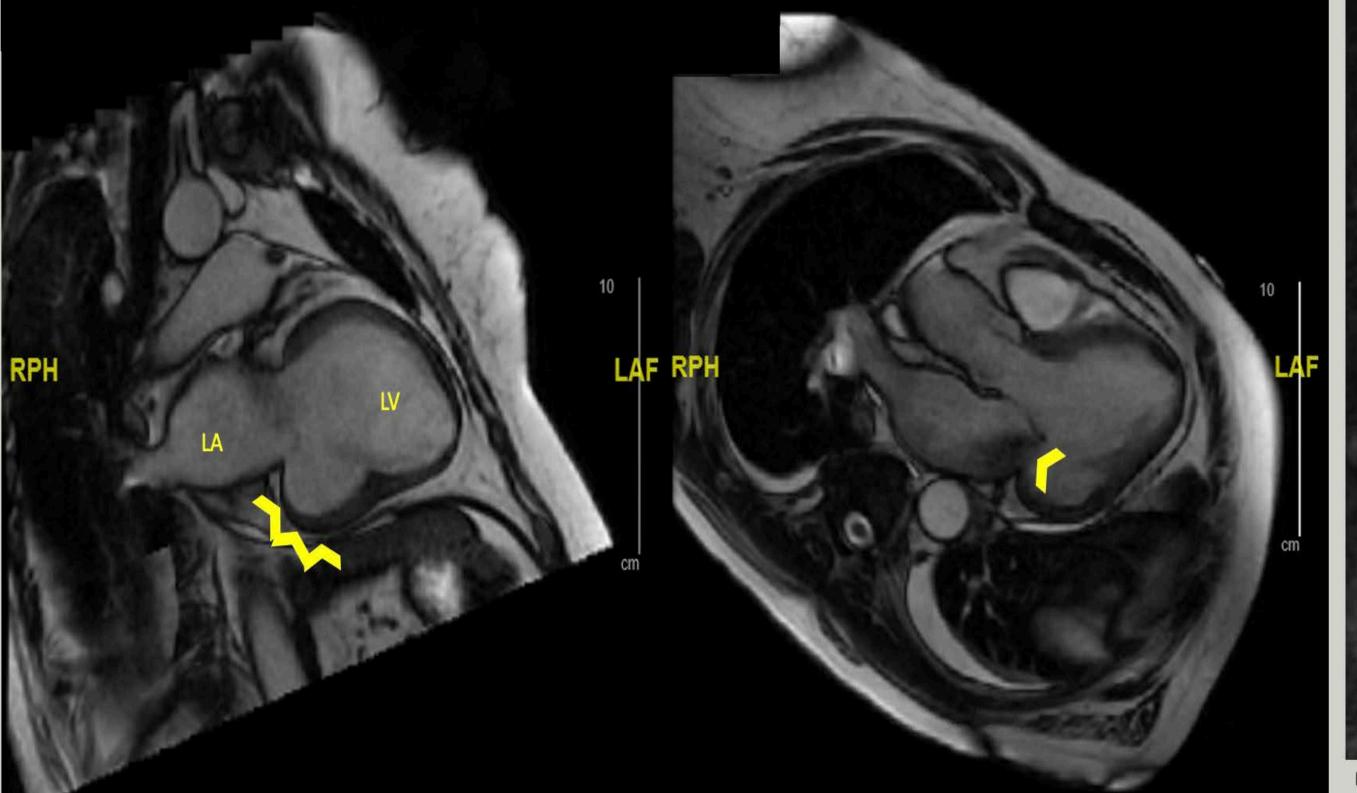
Cardiac magnetic resonance imaging - 2-chamber view (5A) demonstrating the posterior aneurysmal outpouching involving the basal and mid inferior LV wall (arrow heads). Gated 3-chamber view (5B) showing the posterior directionality and grey-black darkening of blood of MR jet (arrowhead).
